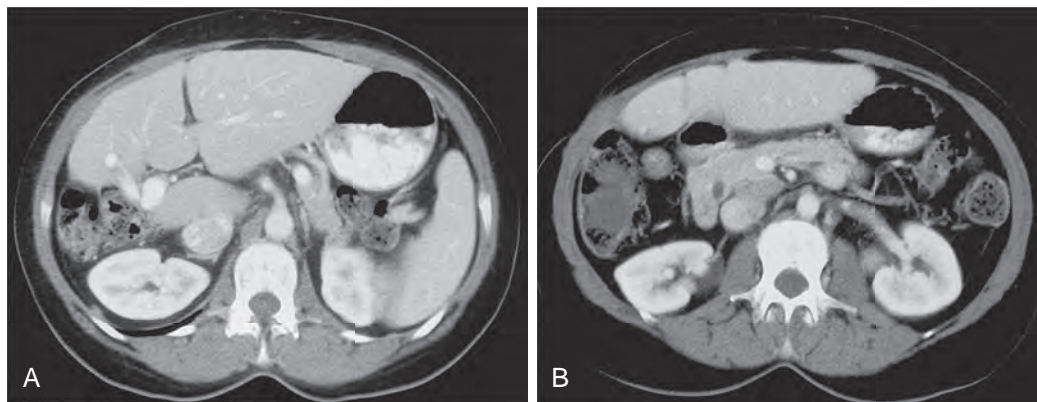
Agenesis of the right hepatic lobe. A. CT reveals agenesis of the right lobe of the liver with compensatory hypertrophy of the left lobe. B. On a more inferior image, only the left lobe of the liver is identified. The colon occupies the bed of the right hepatic lobe.
